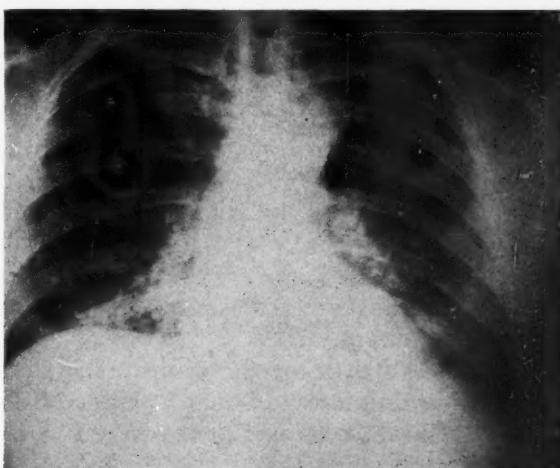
Chest roentgenogram of Case II, J. V., three months after onset of symptoms.
